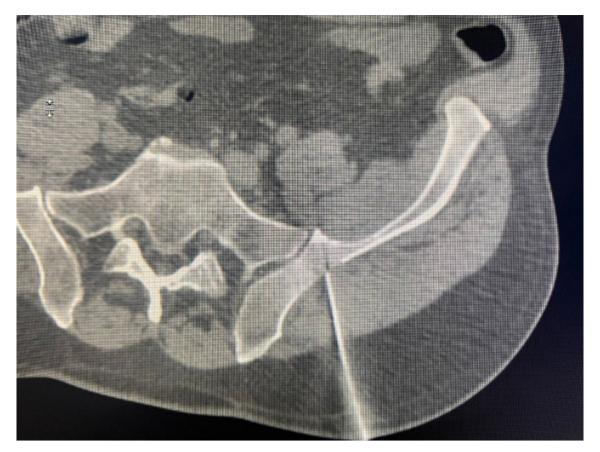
Computed tomography (CT) showing puncture site in osteoblastic lesion on the left iliac bone
